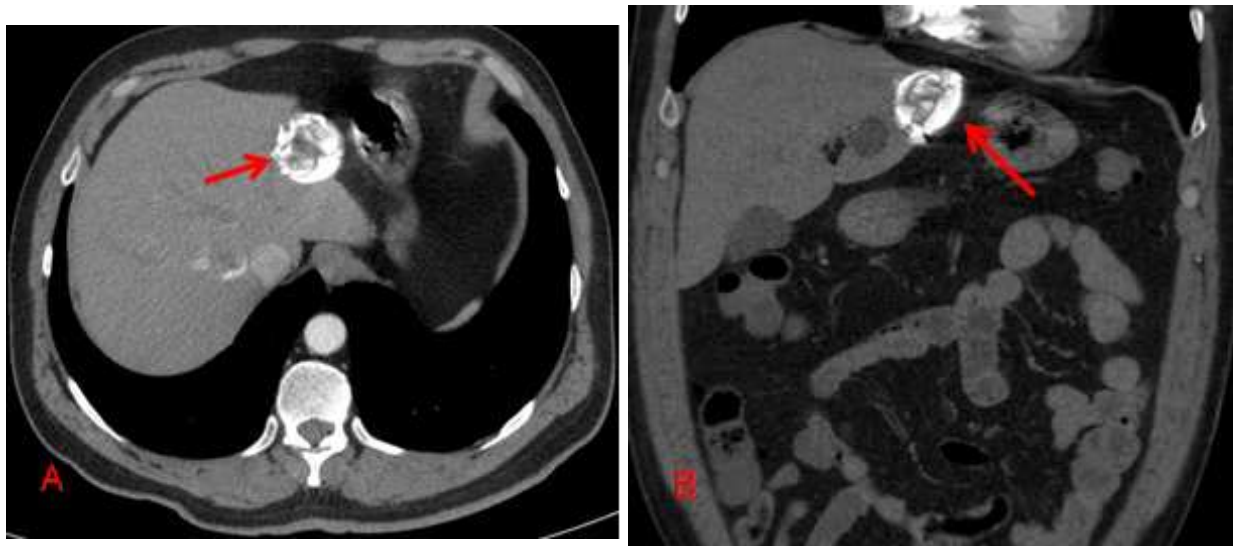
A, B: CT axial (A) and coronal (B) images show hyperdense calcified cyst hydatid (arrows) (Gharbi type 5, WHO CE 5) located at the left liver lobe. Another smaller hypodense cyst hydatid lesion (arrowhead) can be seen on the coronal plane.
